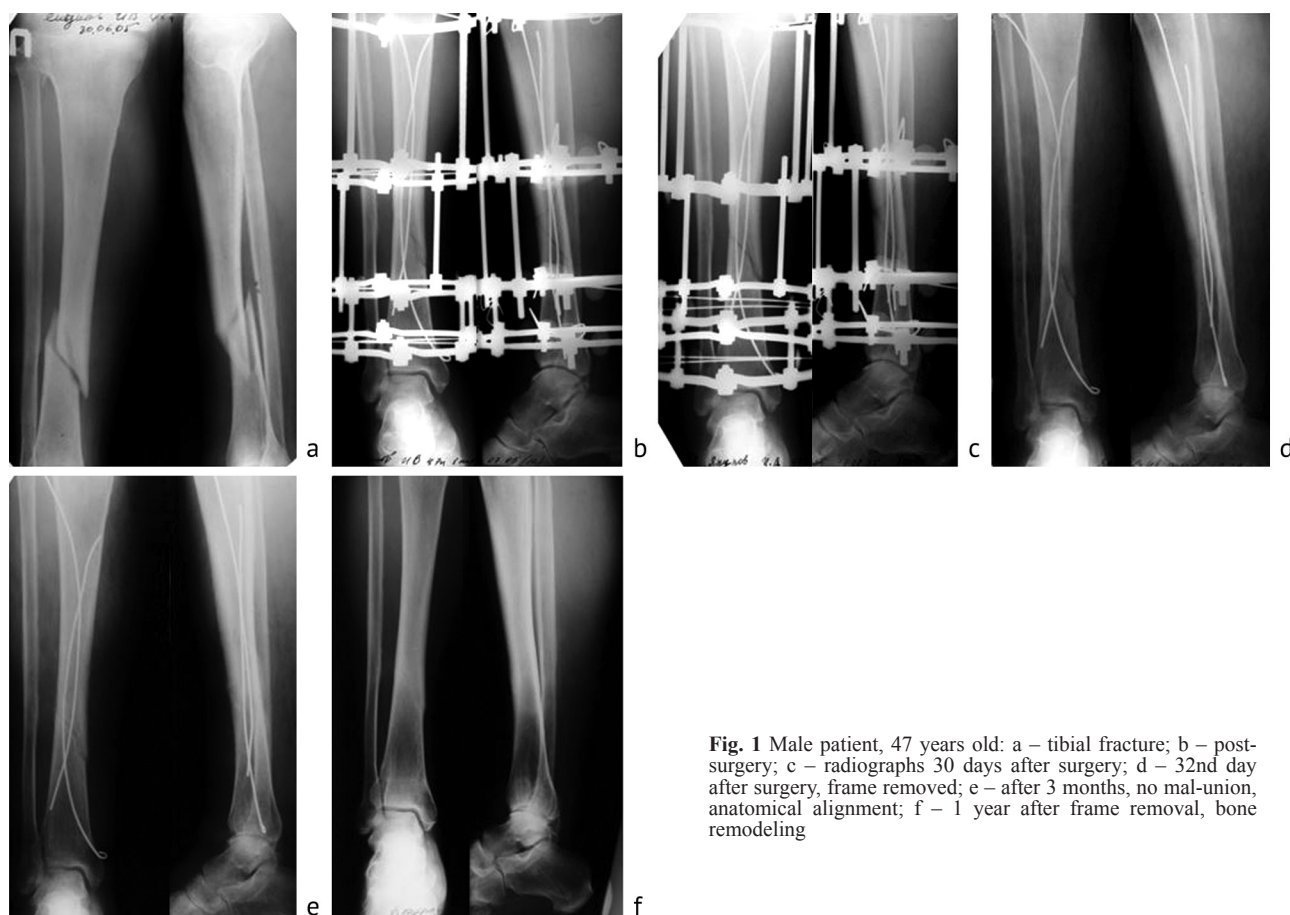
Male patient, 47 years old: a – tibial fracture; b – post-surgery; c – radiographs 30 days after surgery; d – 32nd day after surgery, frame removed; e – after 3 months, no mal-union, anatomical alignment; f – 1 year after frame removal, bone remodeling
